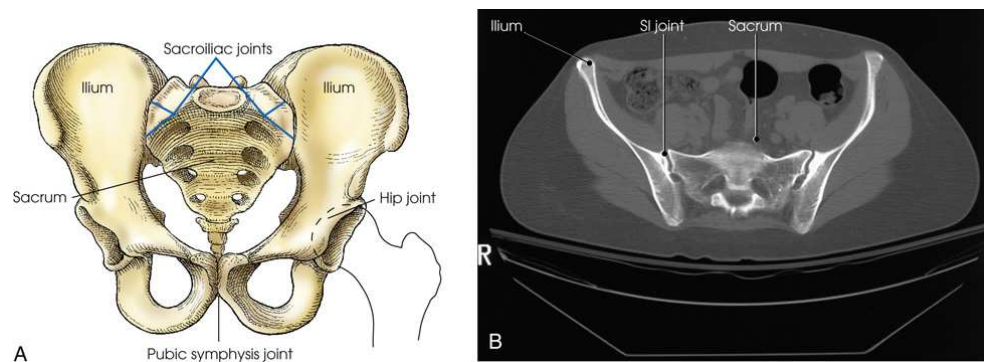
(A) Joints of pelvis and upper femora. (B) Axial computed tomography (CT) image of pelvis showing SI joints. Note 25- to 30-degree angulation of joint. B, Modified from Kelley L, Petersen CM. *Sectional anatomy for imaging professionals*. ed 2, St Louis: Mosby; 2007.
